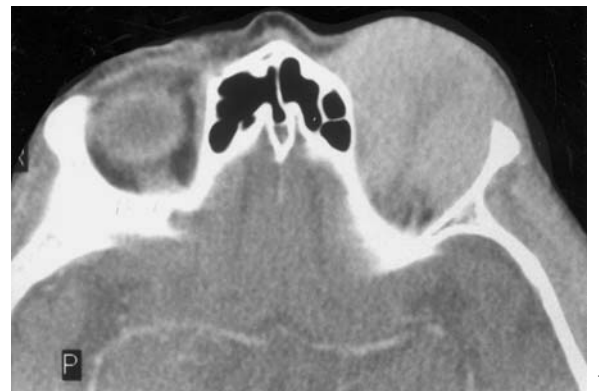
An 86-year-old woman with chronic blepharo-conjunctivitis of the left eye and known NHL for the past 9 years. Diagnosis: NHL lymphoma. CT: A axial view with preseptal and postseptal orbital involvement (infiltration of the lateral external muscle) and extraorbital infiltration of the temporal muscle. b Axial view of the upper orbit showing involvement of the lacrimal gland and the medial upper orbit. Note the slight hypodensity of the uninvolved, but bilaterally compressed superior rectus muscle
